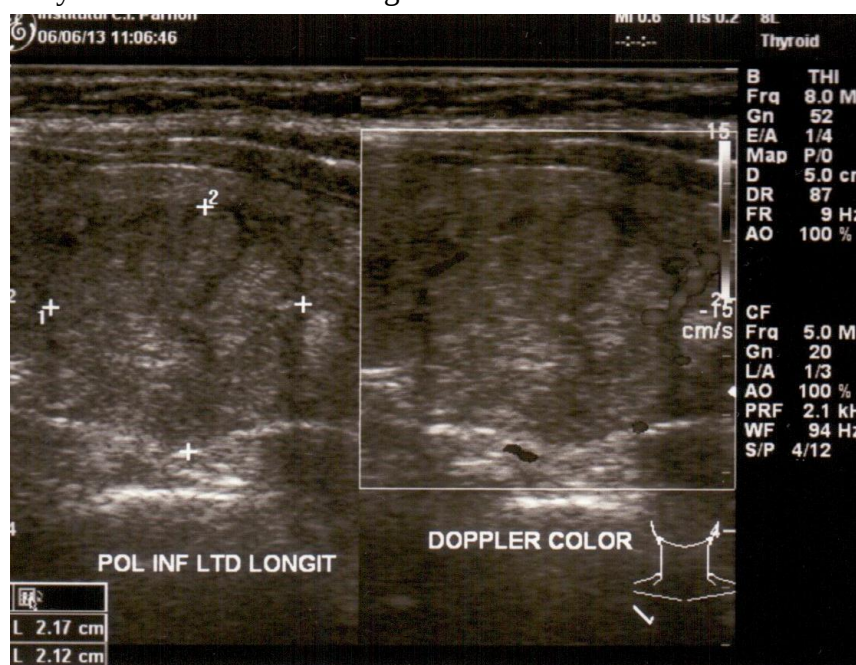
Thyroid ultrasound aspect of nodular goiter.
